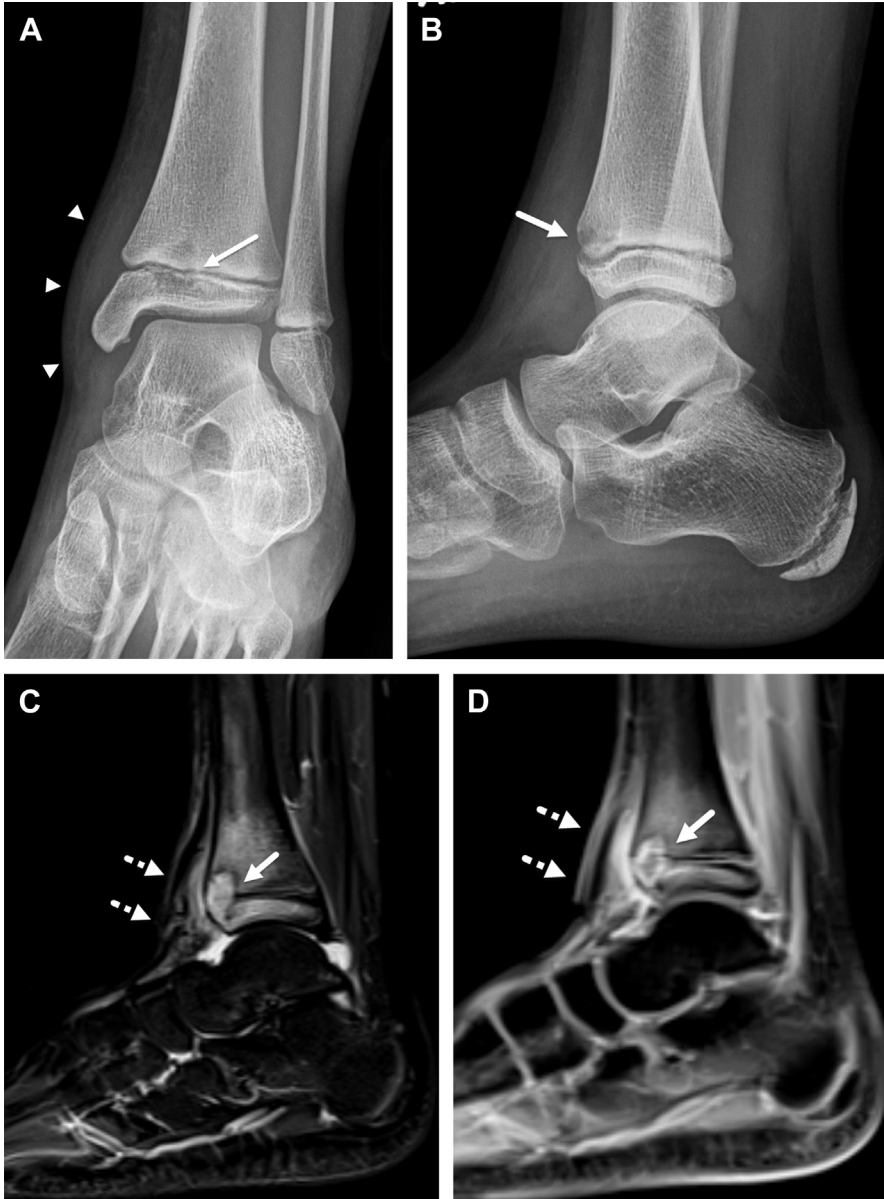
An 8-year-old girl with left ankle pain and prior history of trauma 2 weeks earlier. (A) Frontal and (B) lateral radiographs of the ankle demonstrate ill-defined lucency (arrow) across the anterior distal tibial metaphysis and epiphysis with adjacent soft tissue swelling (arrowheads) concerning for osteomyelitis rather than a fracture. (C) Sagittal MR short-tau inversion recovery (STIR) sequence MR image demonstrates well-demarcated focal area of abnormal high signal intensity (arrow) corresponding to radiographic abnormality and adjacent soft tissue fluid collection (interrupted arrows). (D) Postcontrast T1 fat-saturated MR image shows a rim enhancing lesion (arrow) confirming osteomyelitis with anterior tibial cortical destruction and soft tissue abscess (interrupted arrows). Aspiration and drainage of the tibial abscess showed purulent material and growth of *Aggregatibacter aphrophilus*.
